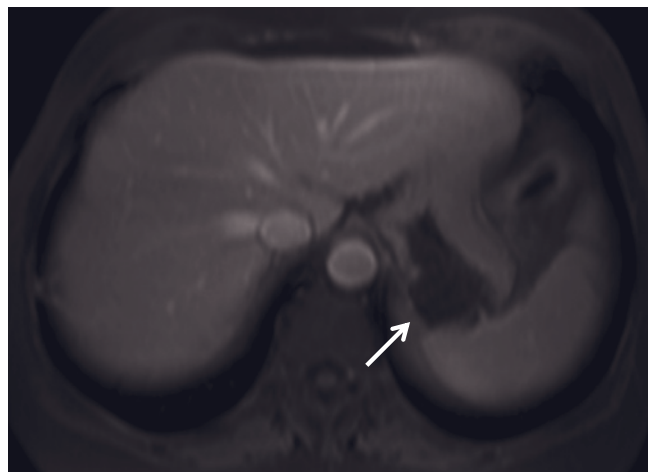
Gastric diverticulum. Transverse T2-weighted SS-ETSE (a) and 90-s postgadolinium fat-suppressed SGE (b) images. A small cystic thin-walled mass (arrow, a) is shown, which is high signal intensity and intimately related to the posterior aspect of the cardiac portion of the stomach. On the 90-s postgadolinium image (b), the diverticulum appears signal void with a thin enhancing wall (arrow, b). (Reprinted with permission from Marcos HB, Semelka RC: Stomach diseases: MR evaluation using combined T2-weighted single-shot echo train spin-echo and gadolinium-enhanced spoiled gradient-echo sequences. *J Magn Reson Imaging* 10: 950-960, 1999.) Transverse (c) and coronal (d) T2-weighted SS-ETSE in a second patient. A small posterior gastric diverticulum (arrow, c) is seen in the fundus of the stomach. T2-weighted single-shot echo-train spin-echo (e), T1-weighted postgadolinium early arterial-phase SGE (f) and T1-weighted postgadolinium fat-suppressed interstitial-phase 3D-GE (g) images demonstrate a broad-based gastric diverticulum (arrows, e-g) in the posterior aspect of the cardia portion of the stomach in another patient. The diverticulum shows high signal on T2-weighted image (f), and thin enhancing wall is appreciated on the interstitial phase (g).
